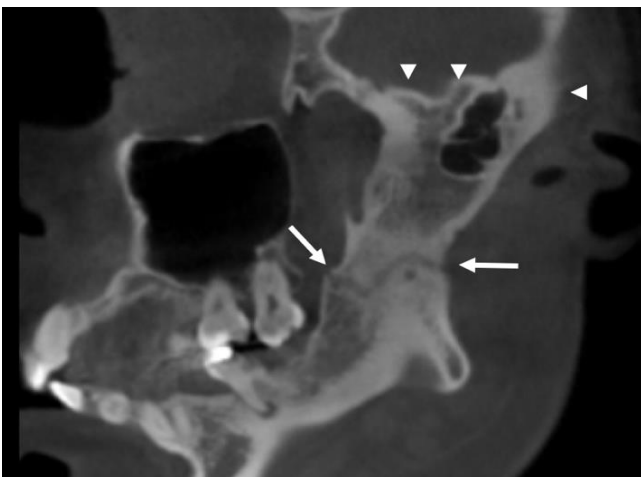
Sagittal view with CBCT demonstrating complete osseous ankylosis (arrowheads) and extension of the radiolucent band in the mandibular body between the posterior and anterior mandibular ramus edge (arrows).
